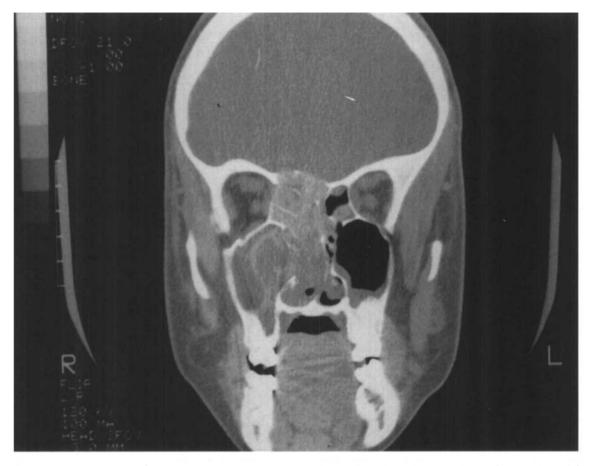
CT scan demonstrating unilateral Curvularia AFS affecting multiple right ethmoid sinuses. Expanding inspissated fungal debris has eroded the medial wall of the right maxillary sinus, the lamina papyracea, and the ethmoid roof, deviating the nasal septum to the left. The opacified sinuses display a heterogenous character.
